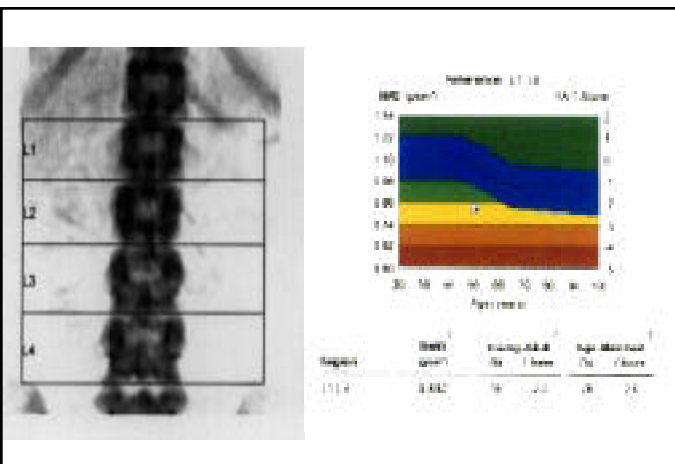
Dual x-ray absorptiometry scan of lumbar bone mineral density (BMD) in a 50-year-old patient with osteopenia (-2.2 SD). YA - young adult, L1-L4 - region
